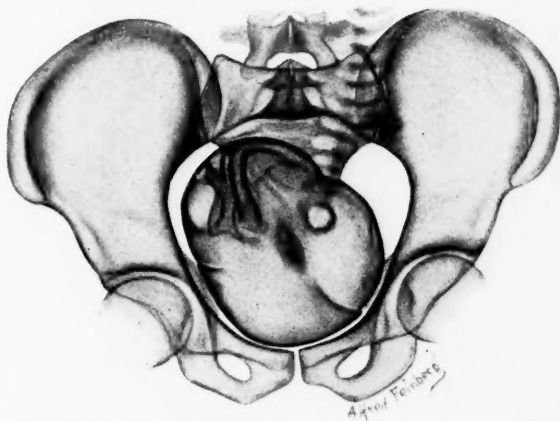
Second x-ray examination later in labor (same case as Fig. 10). The fetal head has been carried forward and downward into the fore-pelvis by the influence of the position of the lower uterine segment. As it is carried into the fore-pelvis, close to the symphysis, it has adapted itself to the narrow fore-pelvis by rotating to the L. O. A. position.
